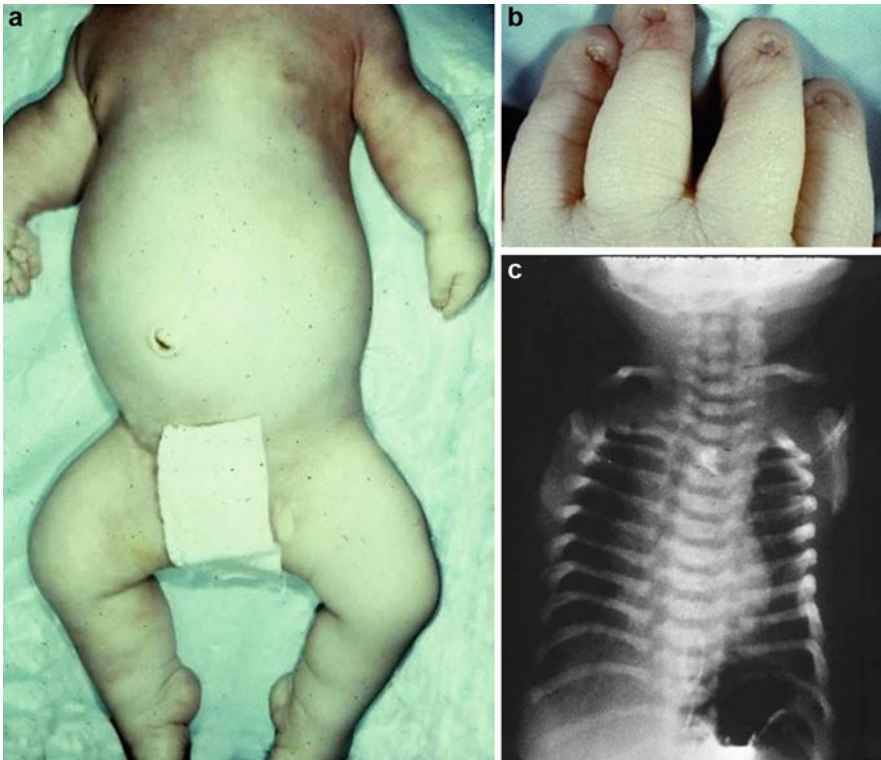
(a–c) A neonate with small chest and short extremities. The fingernails are small and deformed. The baby had six fingers on each hand. Radiograph of the chest shows short ribs but the vertebral bodies are normal
